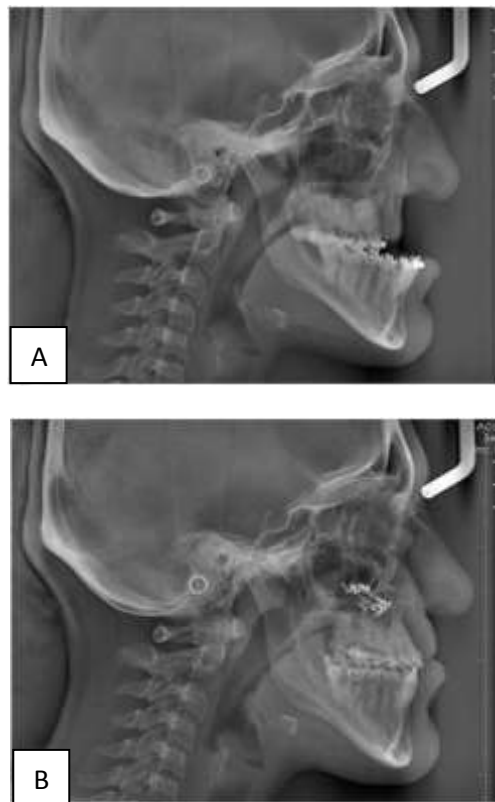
Lateral cephalometric radiograph of the patient: (A) Before distraction osteogenesis. (B) After completion of orthodontic treatment.
